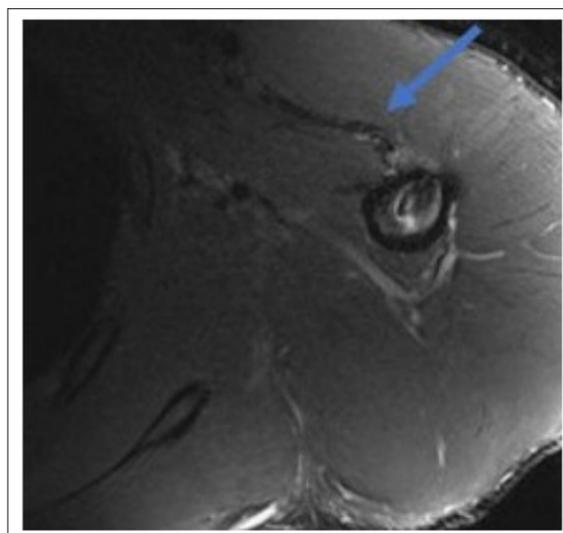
Follow-up MRI at 6 months the tendon graft fixed to the humerus (blue arrow).
